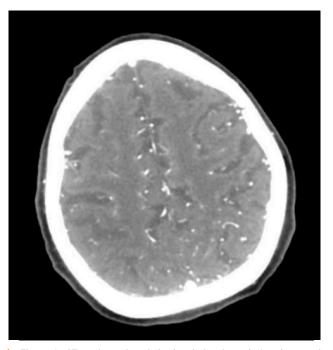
CT angiography of the head showing relative decreased vascularity within the more distal right middle cerebral artery territory.
